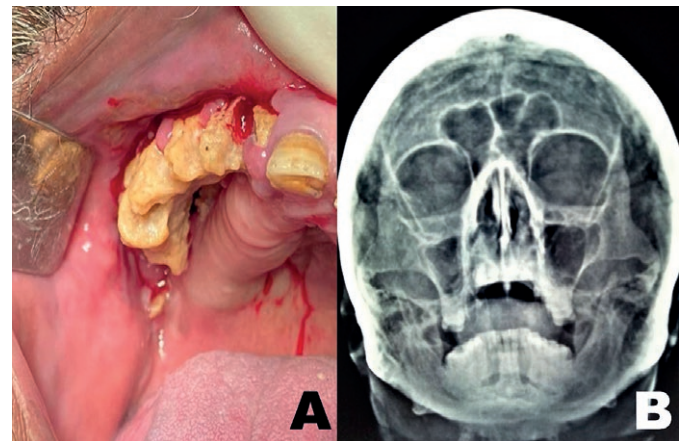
A) Clinical photograph showing necrotic denuded bone; B) Paranasal sinus radiograph showing haziness of right maxillary sinus.
